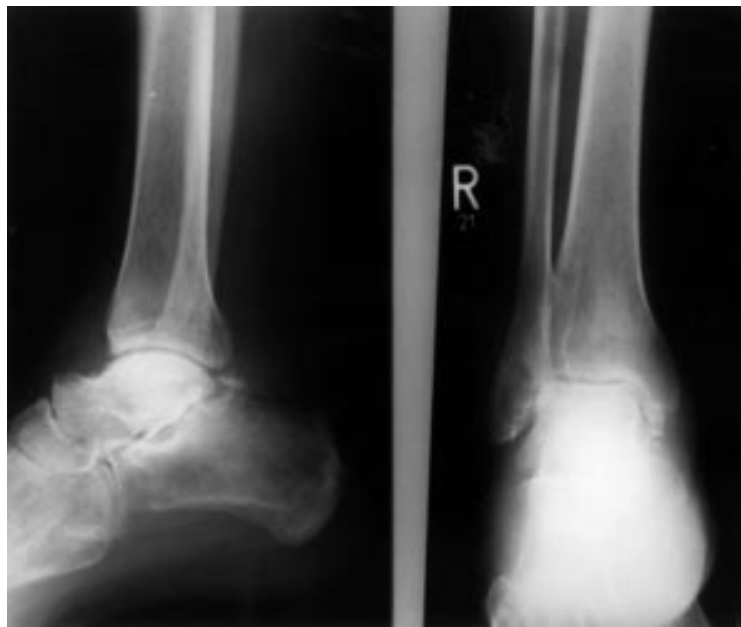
One year postoperative radiographs demonstrating avascular necrosis of the talar body.
